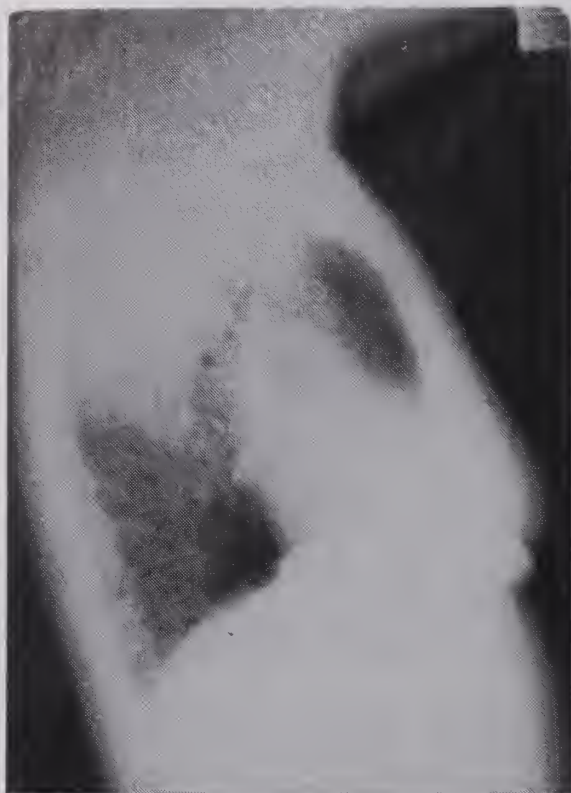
Admit Lateral Chest Xray.
